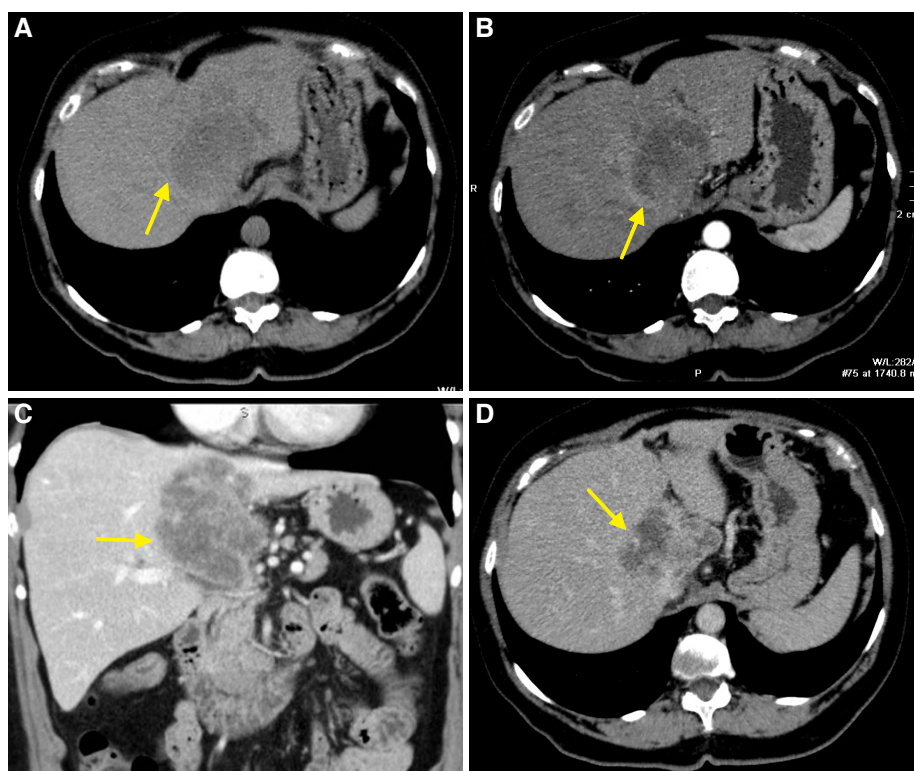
Computed tomography of axial planes obtained in noncontrast phase (A), arterial phase (B), portal phase in coronal plane (C) and axial plane in delayed phase (D). Hepatic mass (yellow arrow) hypodense in noncontrast phase (A), with heterogeneous peripheral enhancement in the arterial phase (B), and portal phase (C), and central uptake in delayed phase (D). This lesion corresponded to cholangiocarcinoma
